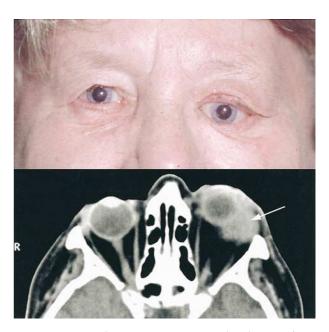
Top: The patient preoperatively shows inferior dystopia of the left globe. Bottom: Axial CT scan of the orbits shows a well-circumscribed lacrimal gland mass (white arrow) in the lacrimal fossa with no bony erosion.
